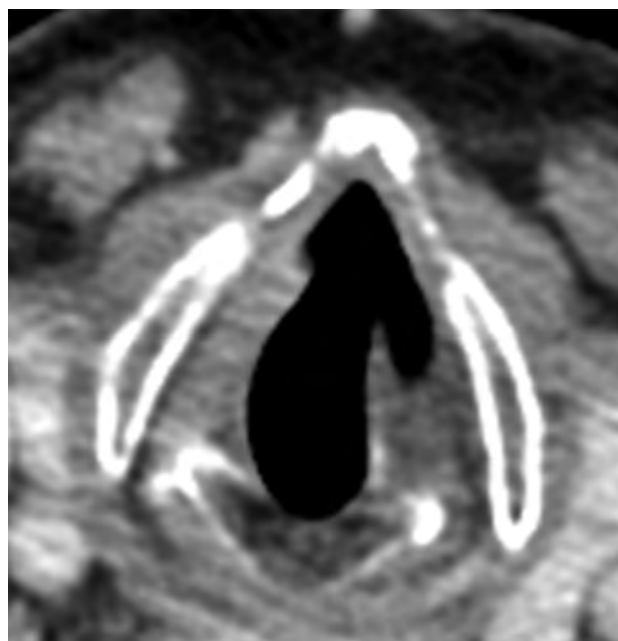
Radiologists' subjectivity on a single axial postcontrast CT scan demonstrates questionable findings of the mushroom sign. This was read by 2 radiologists as negative for this sign and by 1 radiologist as positive for the sign with the left side as the affected side. By laryngoscopic examination, this patient did indeed have left-sided vocal fold paralysis.
